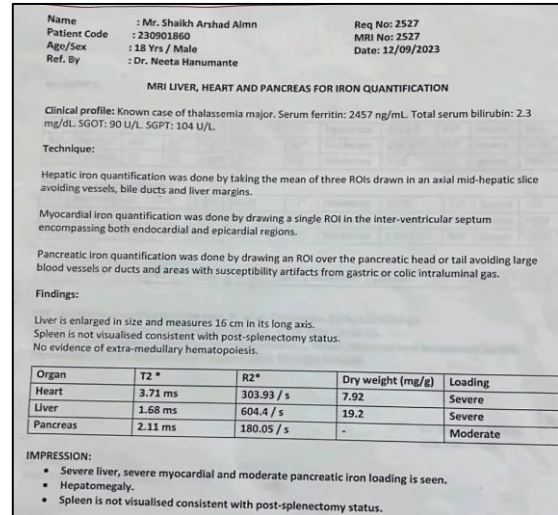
MRI quantification.
